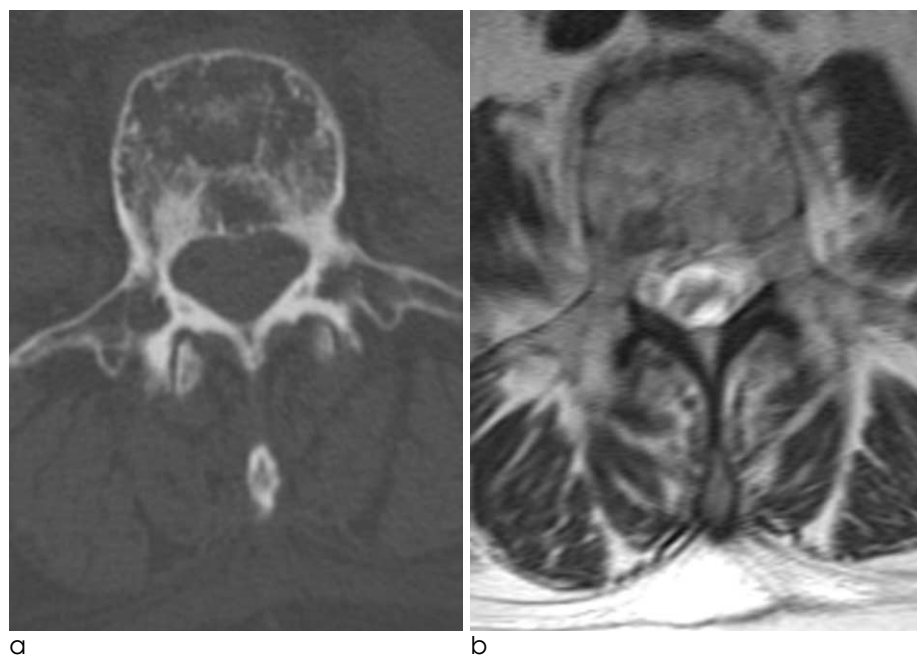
A 56-year-old woman with spine metastases from breast cancer. a. CT axial image shows mixed osteolytic and osteoblastic areas in the vertebra. b. Corresponding T2-weighted axial image of the same level clearly demonstrates that sclerotic areas show hypointensity while osteolytic areas show hyperintensity on T2-weighted MRI.
